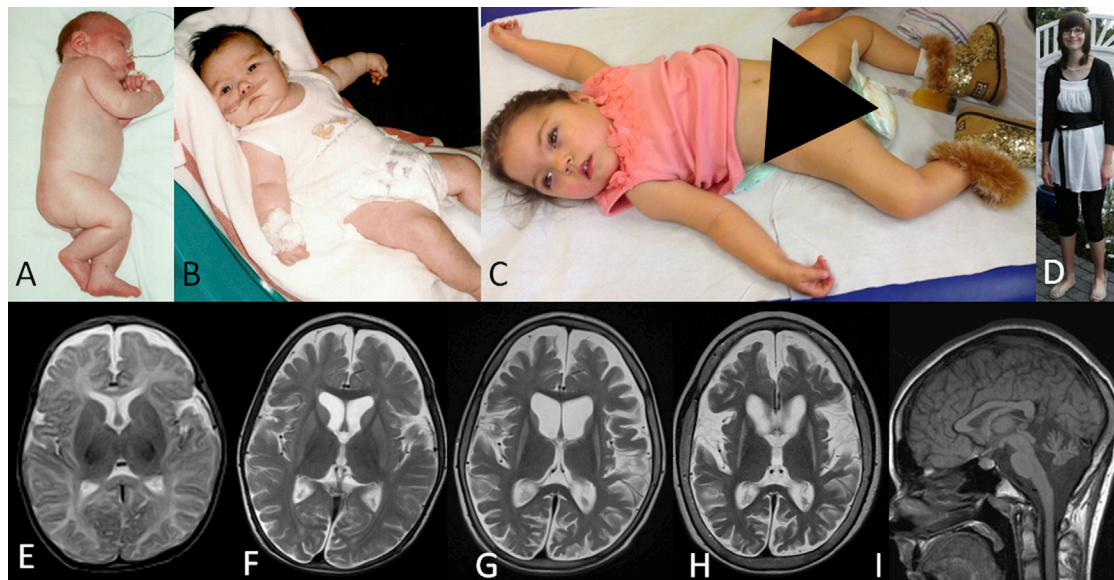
Individual Photographs and MRI Findings
